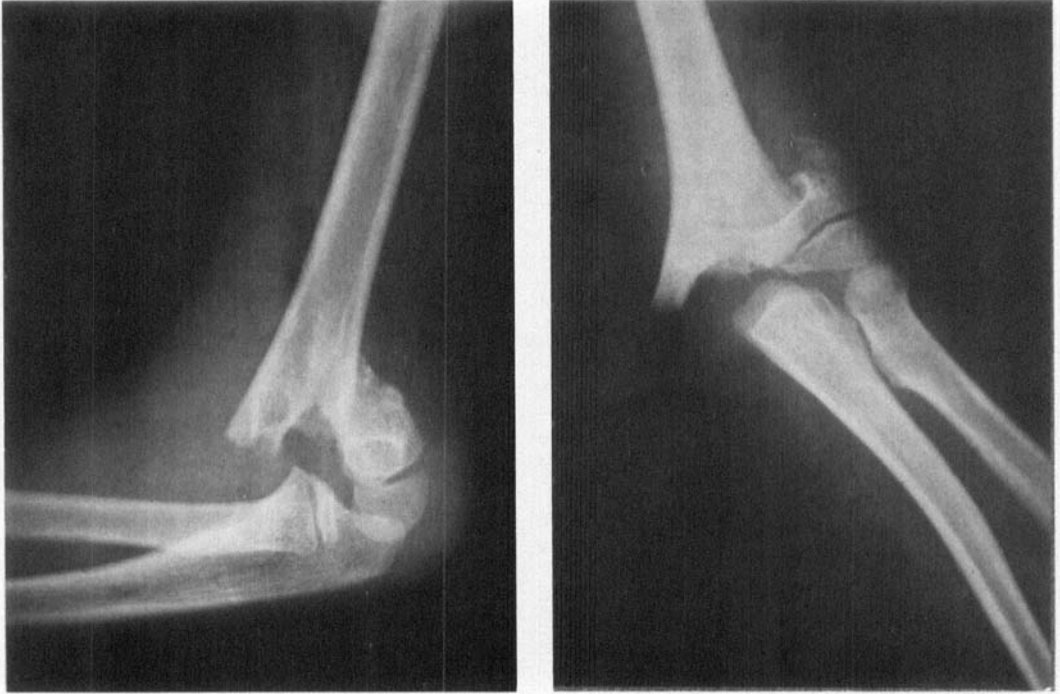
Pre-reduction X-rays, lateral and a-p views.
